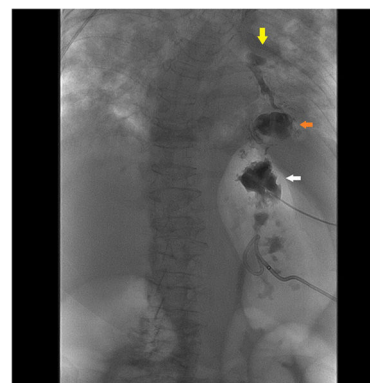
Computed tomography abscessogram.
